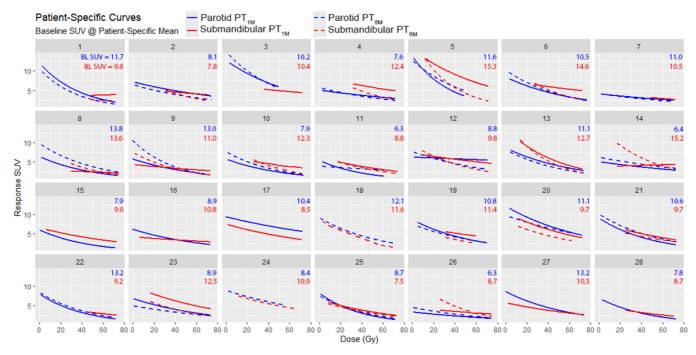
Patient-specific curves for all glands and time points, plotted at each patient's gland type's baseline SUV<sub>mean</sub>.
